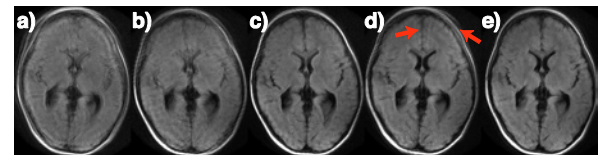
T2-FLAIR image (child #1), slice 14. a) No correction, b) 2D k-space MoCo, c) 2D image space MoCo, d) 3D image space MoCo, e) Intra-blade corr. + 3D image space MoCo. K-space 2D MoCo (b) performed worse than image domain 2D MoCo (c) (consistent for all slices). Arrows show that intra-blade motion needs to be addressed before 3D MoCo, (d) vs. (e).
